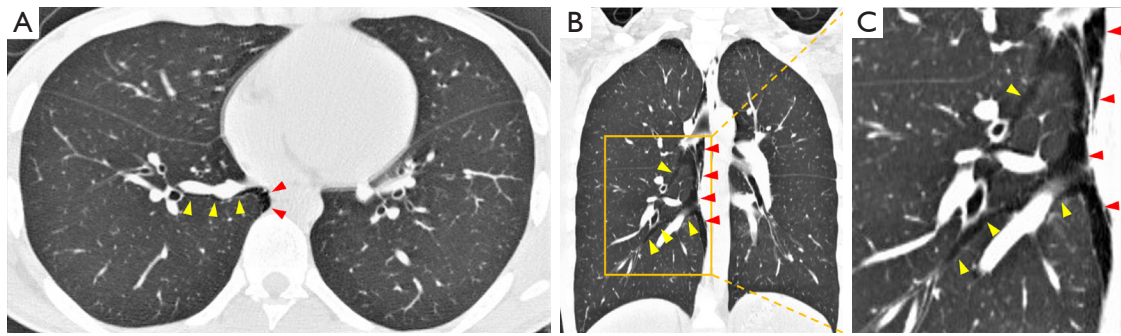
Representative chest computed tomography images of the onset of spontaneous pneumomediastinum in a 15-year-old boy with no trigger factors at onset. (A) Axial image, (B) coronal image, and (C) magnified image of the yellow rectangle in (B) show free air in the mediastinum (red arrowheads) and in the lung parenchyma with the pulmonary vessels and bronchus (yellow arrowheads). Free air had diffusely spread to the wide area of the mediastinum (A,B). However, free air was not seen in the lung parenchyma, except for the limited area of the right lower lobe (B,C). These findings suggest that free air spread from the limited area of the right lower lobe to the mediastinum, which further suggests that the Macklin effect was one of the mechanisms underlying spontaneous pneumomediastinum. The Macklin effect refers to the phenomenon of a large pressure gradient between the alveoli and the lung interstitium inducing alveolar rupture and the subsequent release of free air along the pulmonary vessels and bronchus in the limited area of the lungs coursing toward the mediastinum.
